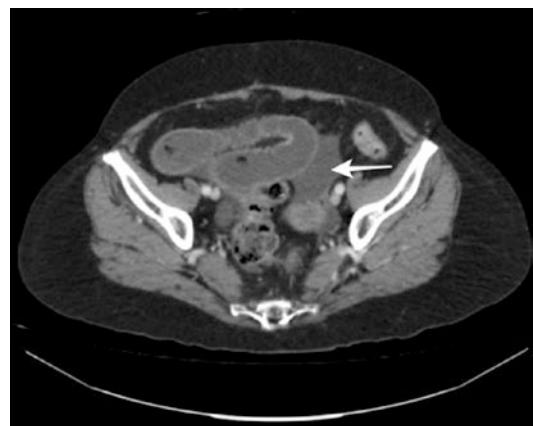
CT imaging of a patient with a small bowel obstruction. Note the fluid-filled dilated loops of bowel. The mucosa can be seen enhancing symmetrically. However, there is free fluid, concerning for ischemia (white arrow)
